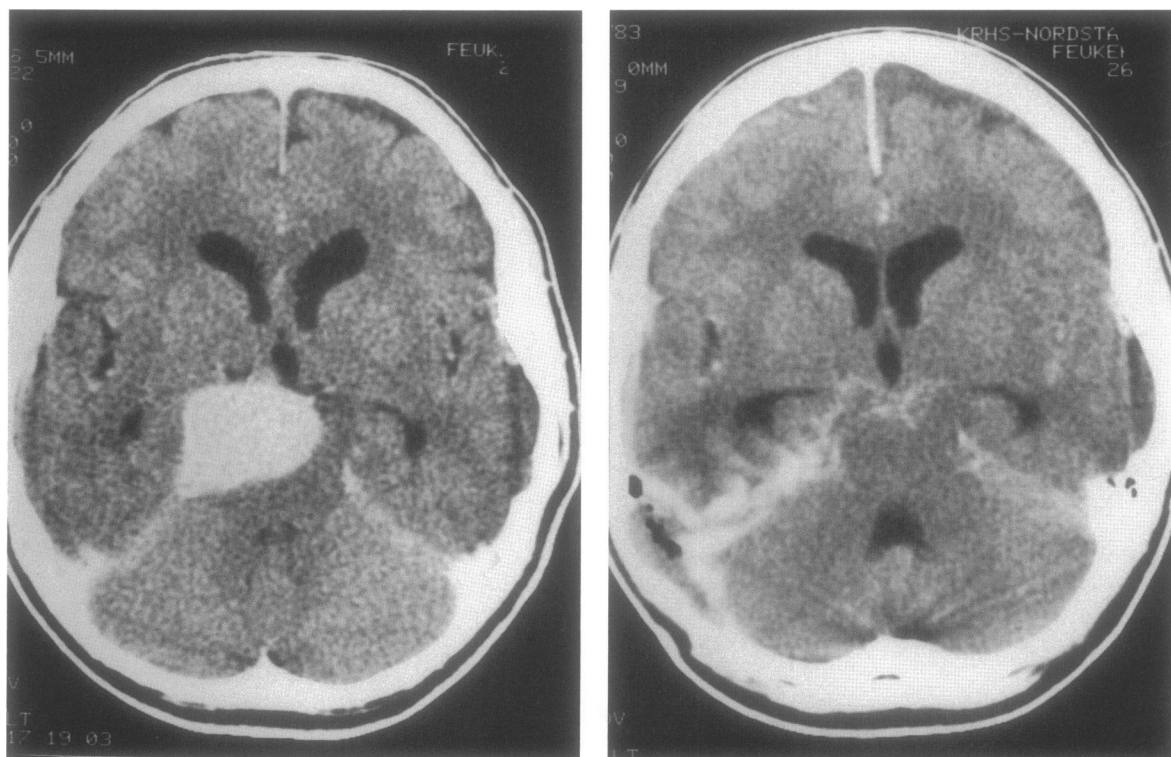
Preoperative (left) and postoperative (right) computed tomography of patient 2.
